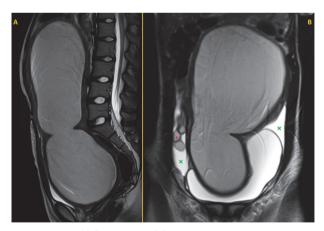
Sagittal (A) and coronal (B) T2-weighted magnetic resonance images showing the extremely large and dilated uterus filled with a hyperintense content as well as the right dilated Fallopian tube (red asterisk) and intraperitoneal free fluid (green crosses), compatible with a massive hematometra associated with hematosalpinx.
